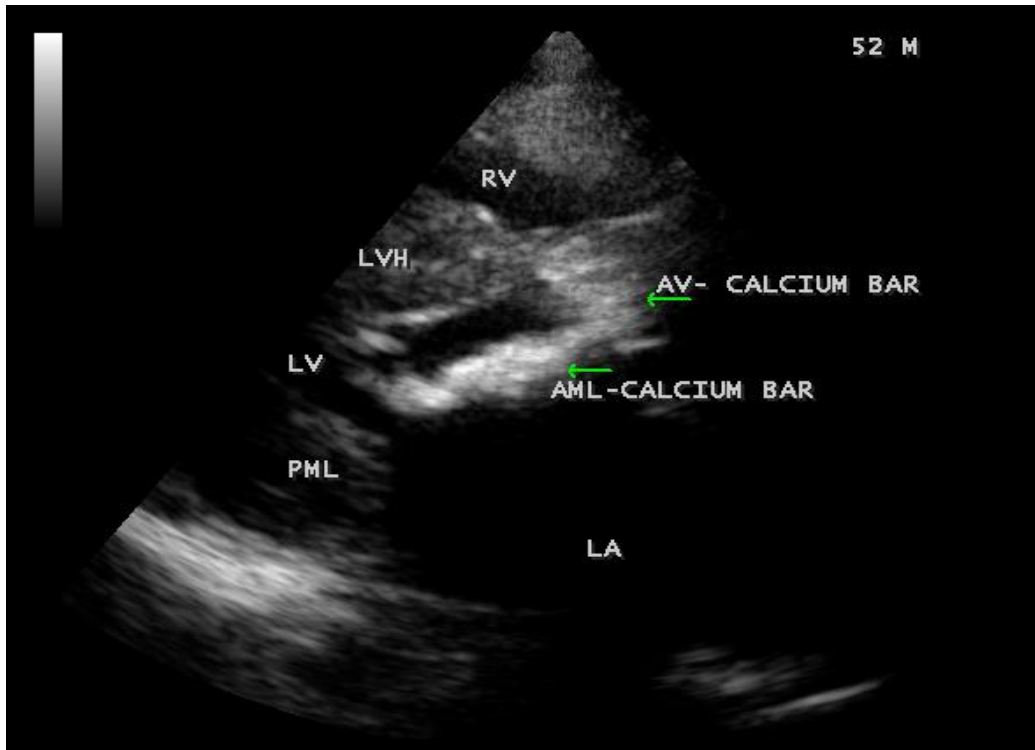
Parasternal long axis view showing the dense calcification of anterior mitral leaflet (AML) with commissural fusion in a 52-year old male.
